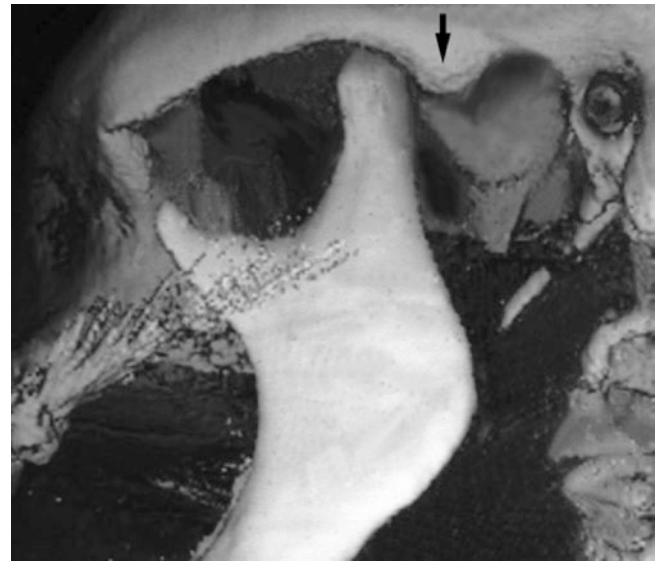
Non-fracture trauma to the mandible; patient with jaw luxation. (A) Panoramic view and (B) oblique sagittal CT image show condyle in front of eminence
